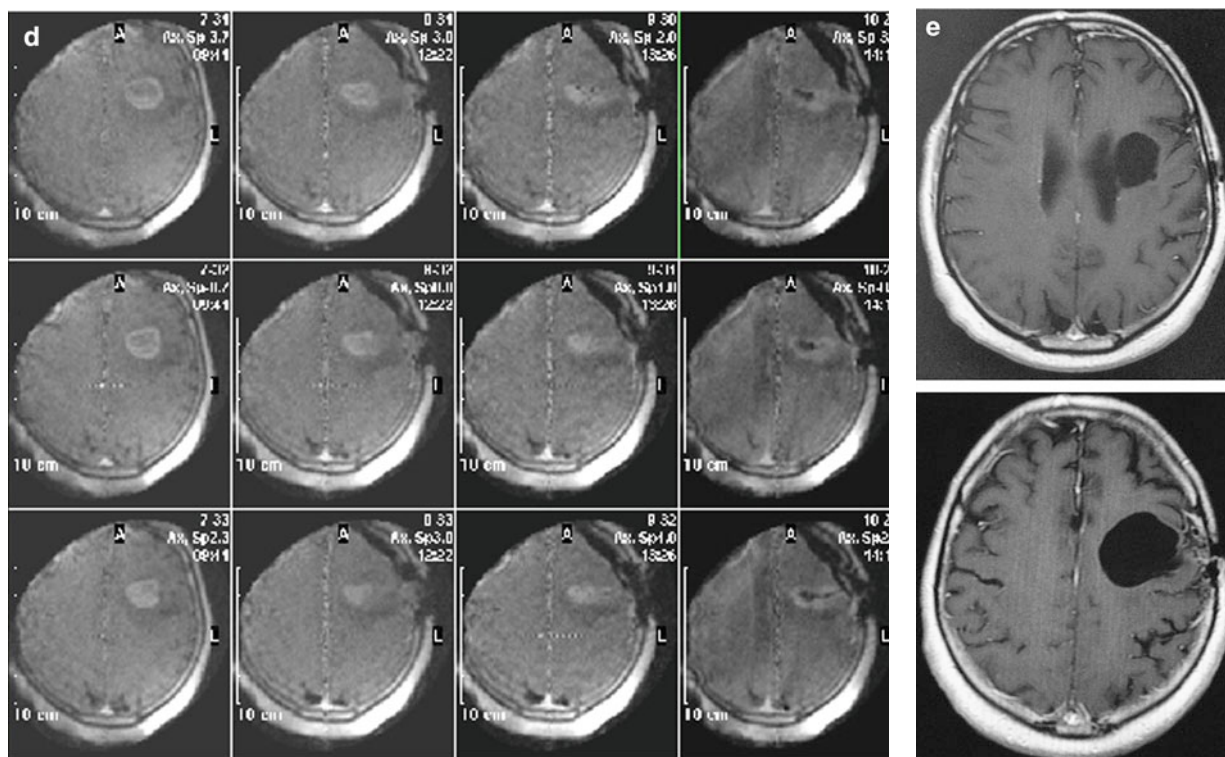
(a) Preoperative T1 weighted postcontrast diagnostic images acquired with 1.5 T MRI scanner demonstrated a left deep seated frontal tumor. (b) T1 weighted postcontrast images acquired with Polestar before surgery. (c) Neuronavigation using the images acquired with Polestar before the beginning of surgery. (d) Intraoperative control MRI images for comparing the extend of resection. (e) Control MRI images 12 months after the operation
